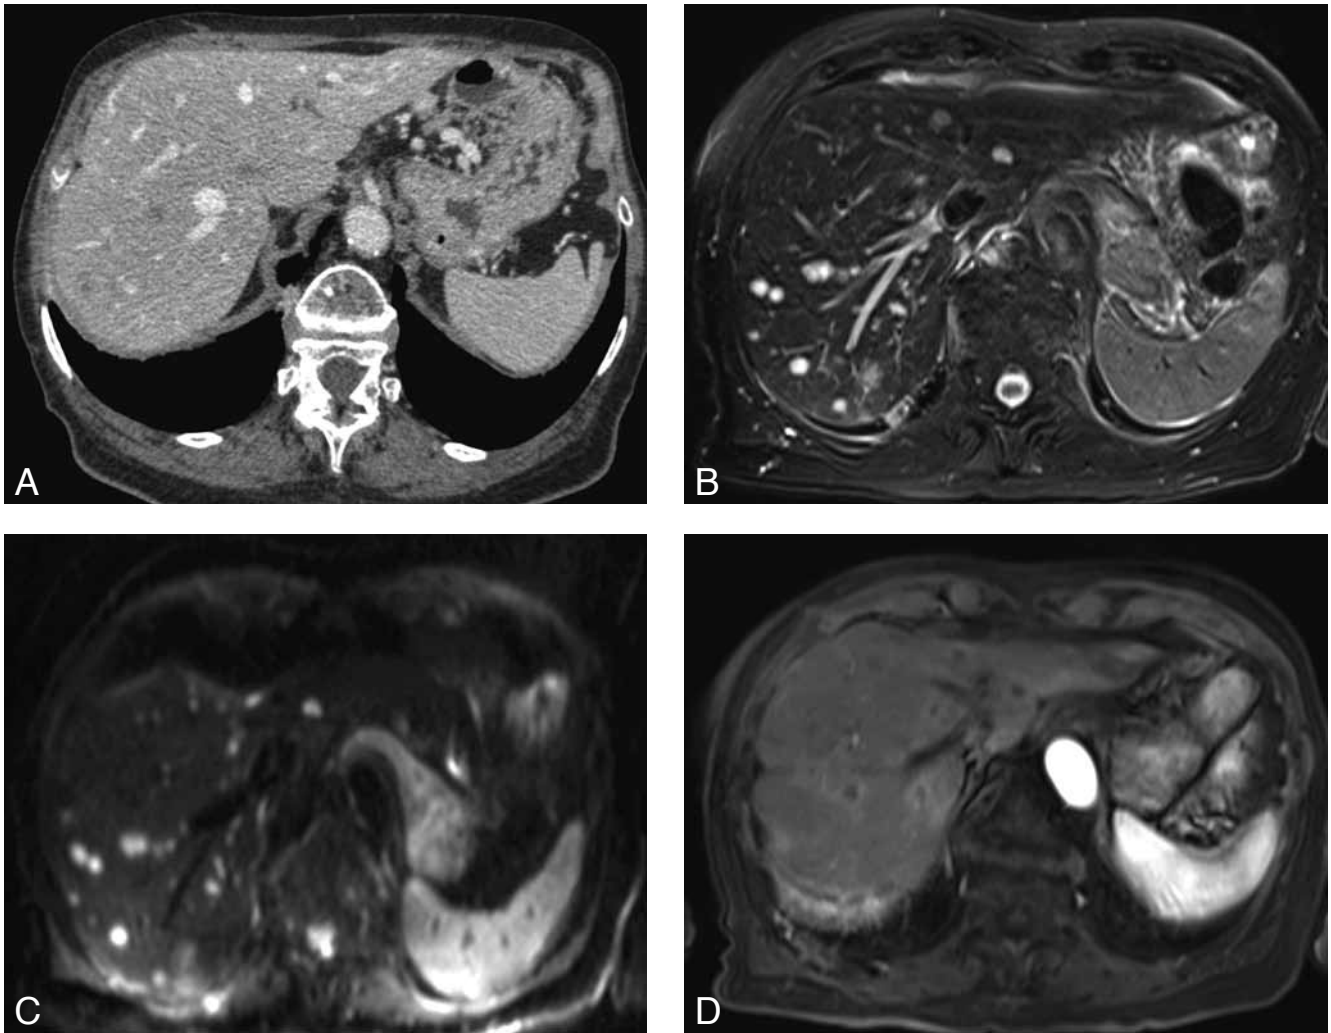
DWI and gadolinium-enhanced MRI at 3.0T is superior to MDCT. A. At MDCT three small metastases are visualized, with low contrast. B. T2w MRI at 3.0T shows many more hyperintense metastases. C. At DWI the lesions are displayed with excellent conspicuity. D. Gadolinium-enhanced MRI shows typical rim enhancement of metastases.
